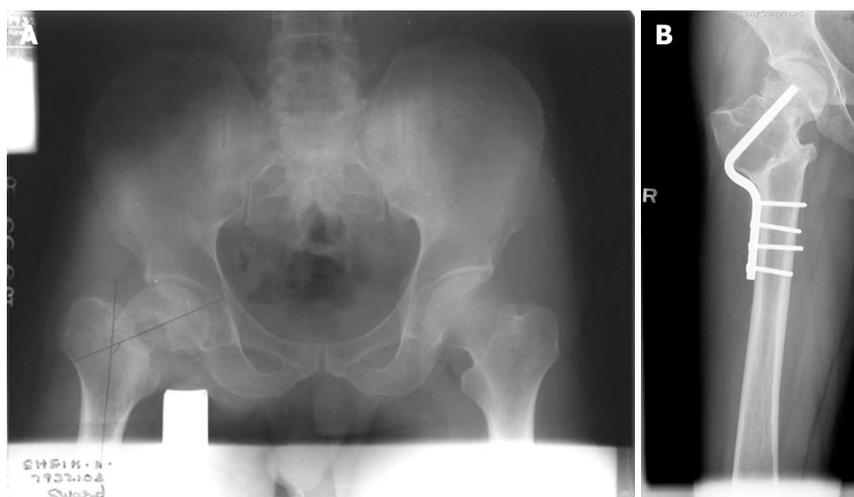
Problems with excess valgus. A: Anteroposterior radiograph of pelvis of a 33-year-old male with a 3-mo-old nonunion neck of femur fracture; B: At 10-year follow-up, showing excess valgus, when the Harris hip score was 68.
